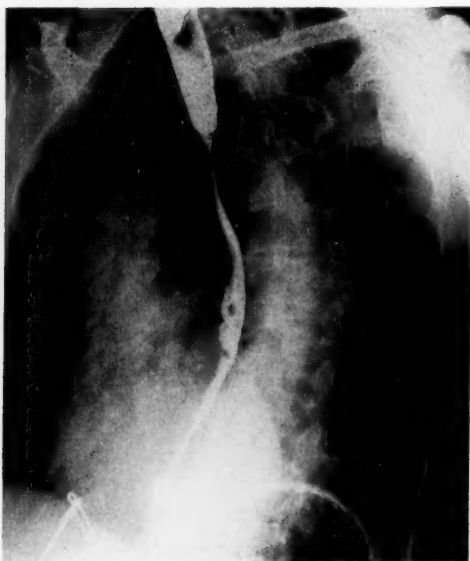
Case 1.—X-ray appearance of esophageal lesions, showing some improvement after bouginage.
